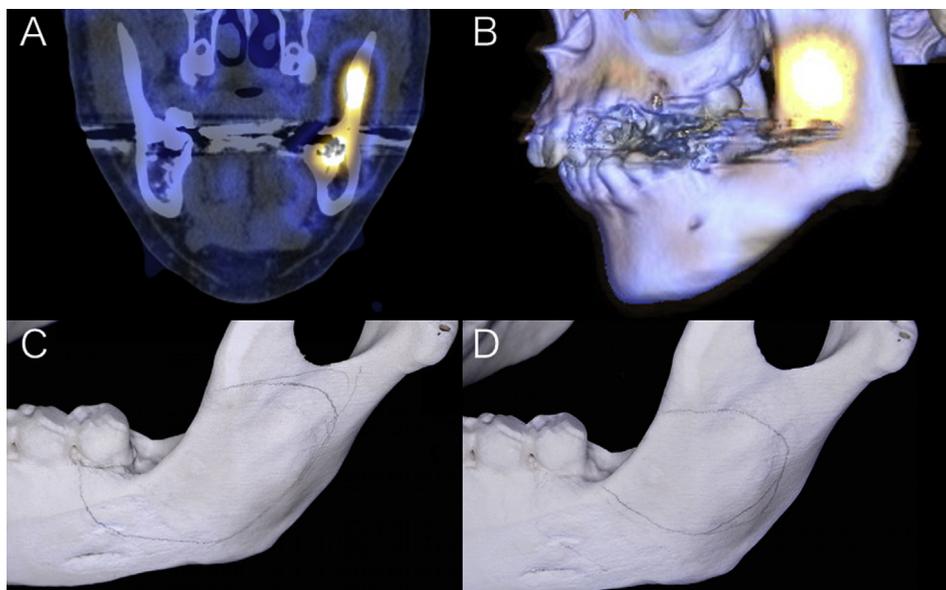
Delineation of the disease area onto 3D-printed jaws by an oral surgeon using references to 2D (A) and 3D SPECT/CT (B) for a patient with carcinoma of the left mandibular gingiva. The same surgeon delineated the virtual disease areas using references to 2D (C) and 3D images (D) with an interval of more than 1 month.
